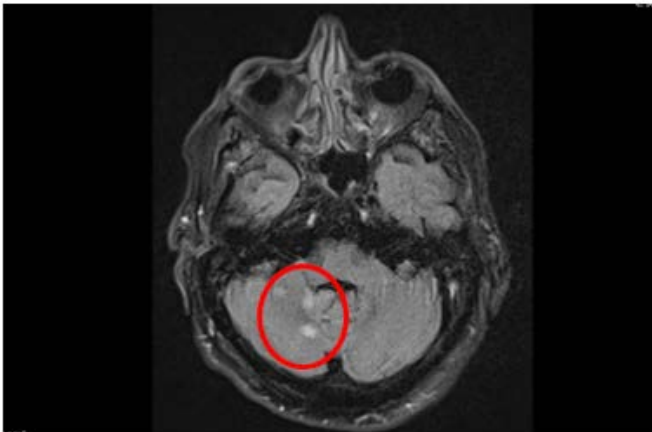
Brain MRI with ischemic lesions in the right cerebellar hemisphere.
